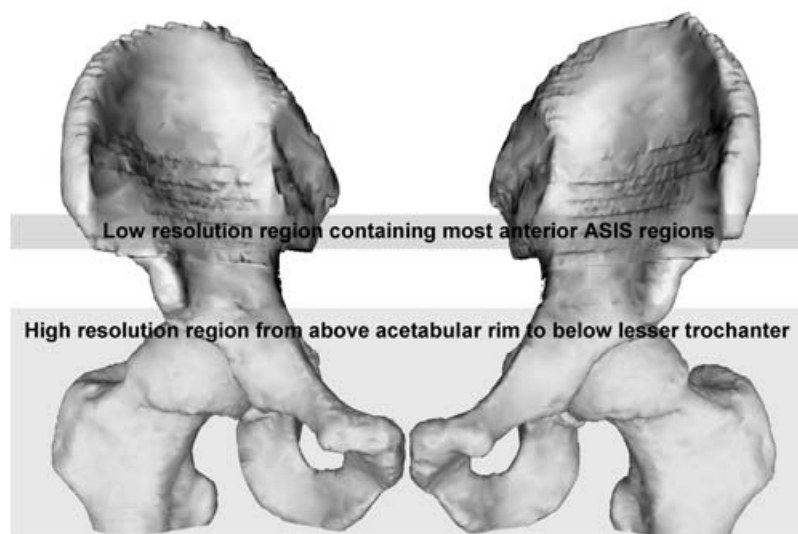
CT scanning regions: upper band, low resolution; lower band, high resolution
